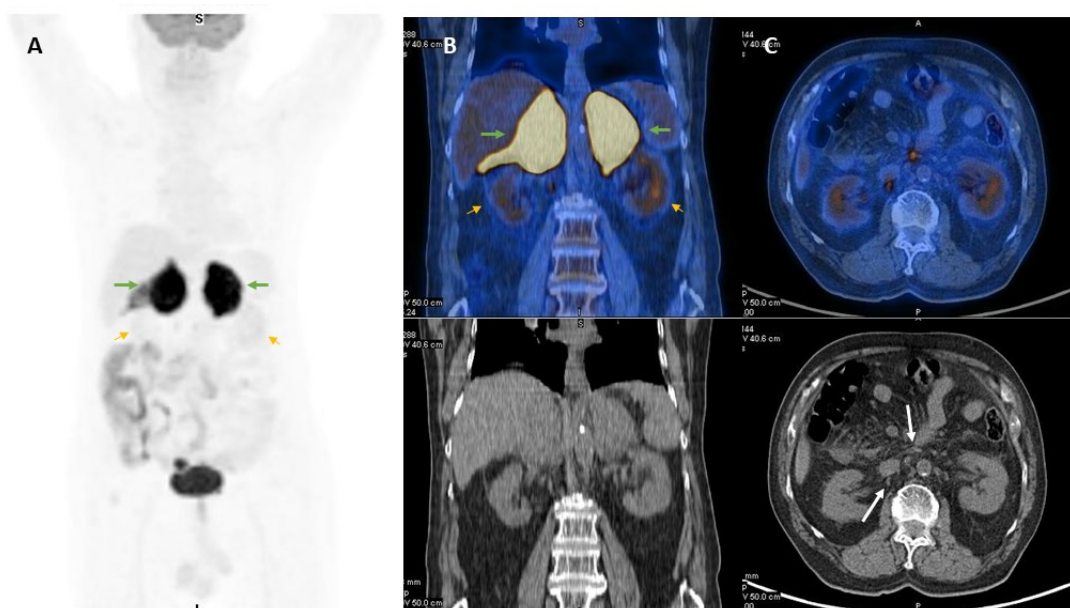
High-intensity uptake in the adrenals (green arrows) may initially be mistaken for the physiological uptake of the kidneys (yellow arrows). Also, mild [¹⁸F]FDG uptake is noted in small lymph nodes in the superior mesenteric and para-aortic regions (C, arrows). No other hypermetabolic or abnormal lesions were identified elsewhere in the body
